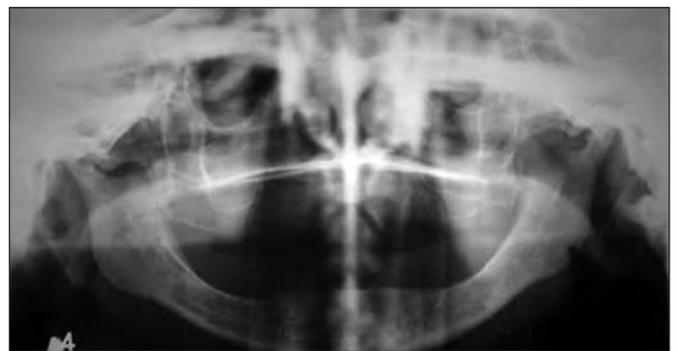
Panoramic radiograph within the normality standards for the age and dental condition of the patient
